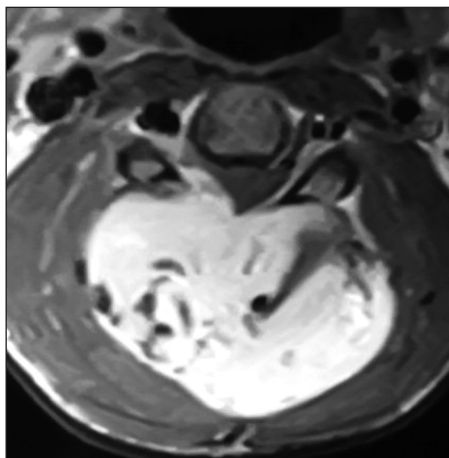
Postcontrast T1-weighted axial magnetic resonance image showing the well-defined enhancing mass extending into both intra- and extra-spinal compartments. Multiple flow voids are noted
